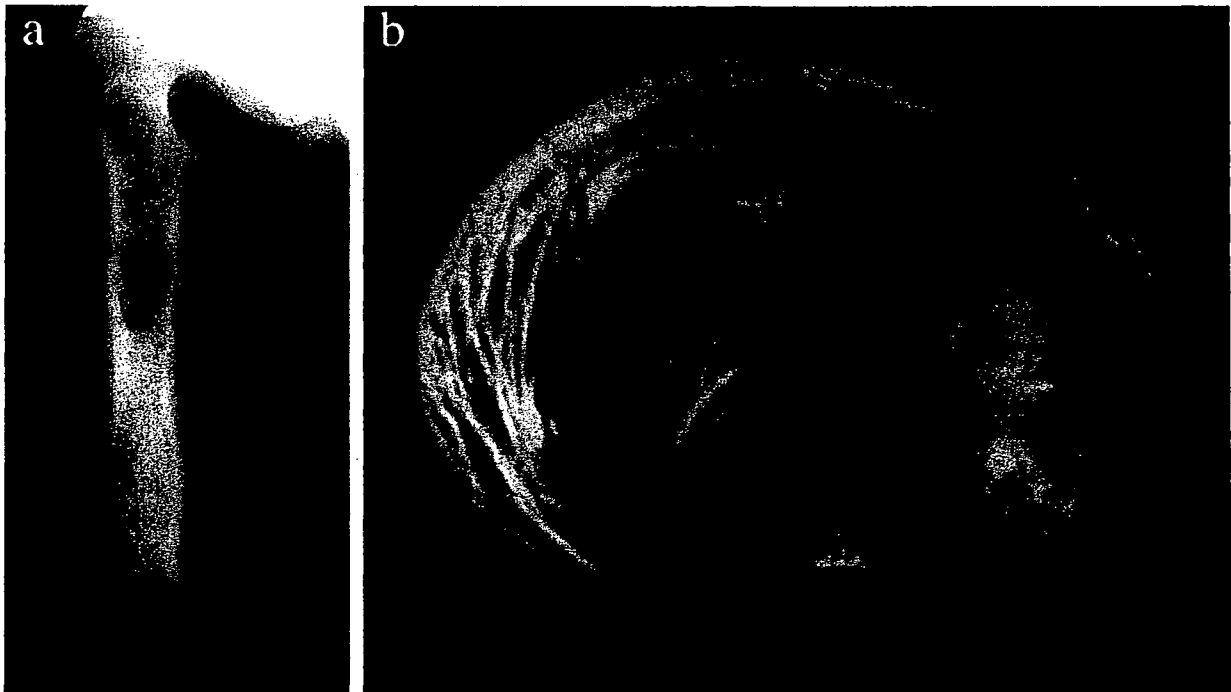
Plain radiograph and T2-weighted magnetic resonance imaging (MRI) of the right thigh. (a) Plain radiograph at the time of the first examination showed osteolytic change, sclerosis and periosteal reaction of the femur with no extra-osseous growth of a tumor. (b) MRI showed a huge tumor with massive extra-osseous growth.
